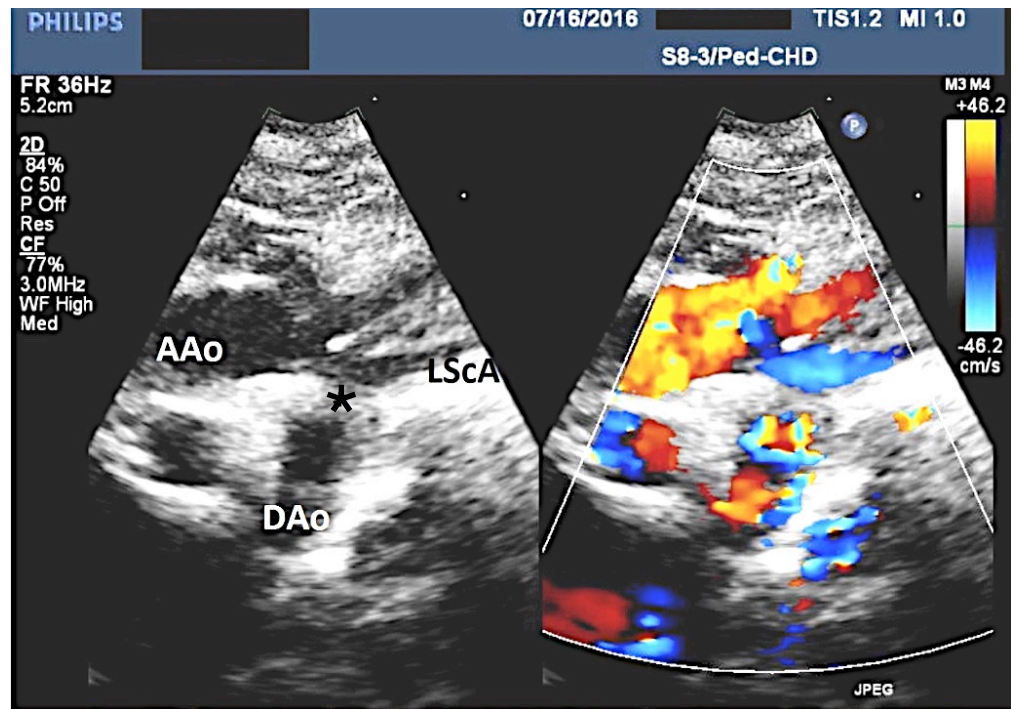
Echocardiogram image of the interrupted aortic arch, with discontinuity of the aorta distal to the left subclavian artery (LScA). AAo = ascending aorta; Dao = descending aorta; * = region of the interruption.
